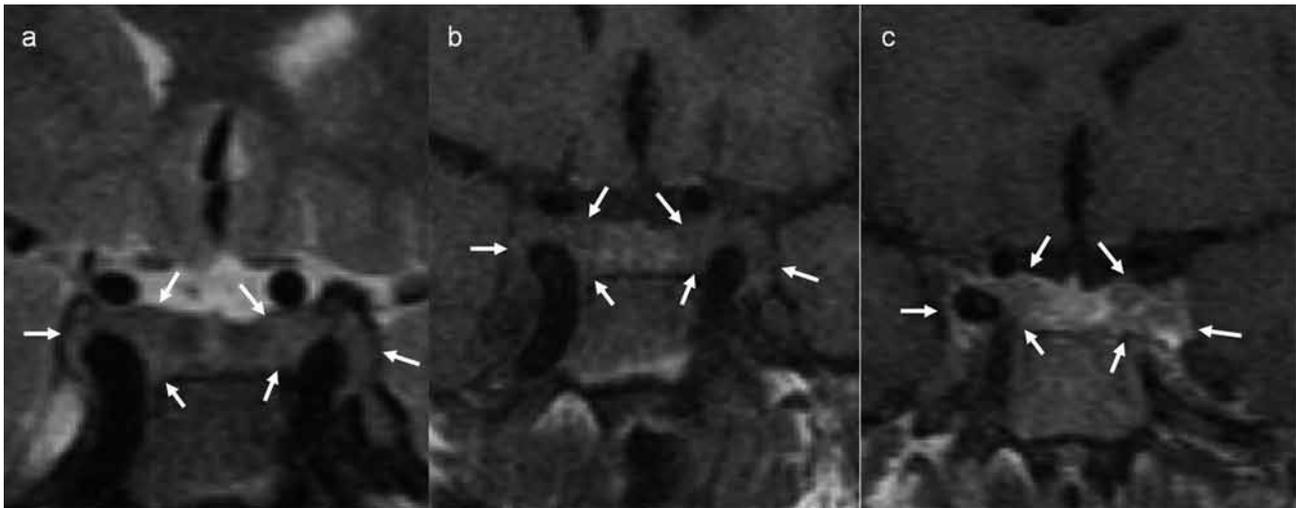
Coronal T2-weighted (a), T1-weighted (b), and contrast-enhanced T1-weighted (c) MR images showing bilateral lesions infiltrating both cavernous sinuses and obliterating the view of their boundary with the pituitary gland (arrows). On the left side, the lesion has directly invaded the left Meckel's cave and significantly surrounded the cavernous segment of the left internal carotid artery (a-c). In contrast-enhanced image (c), the lesions show less and heterogeneous contrast enhancement than the normal pituitary gland.
